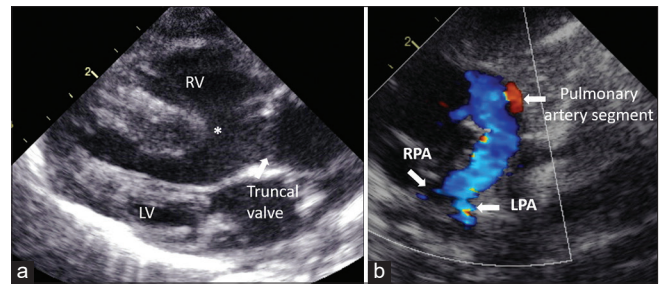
Parasternal echocardiographic views. (a) The arterial trunk is overriding the ventricular septum and the large malaligned ventricular septal (asterisk). (b) After balanced division of the trunk into the systemic and pulmonary pathways, there was a long pulmonary artery segment
